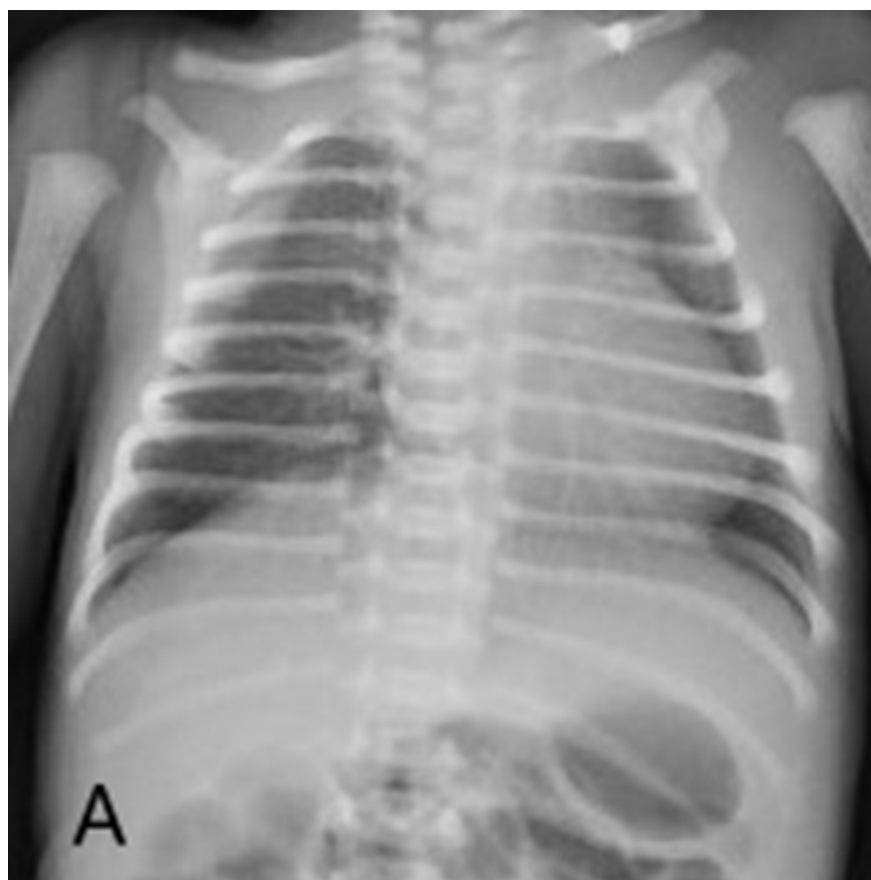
A Chest radiograph taken on birth showing reduced lung permeability and RDS (respiratory distress syndrome). B Chest radiograph taken on 24 hours after birth showed the ventilation status of the lungs was good with using a PS⁺ invasive ventilator. C Chest radiograph taken on 48 hours after birth showed no obvious abnormality. D Chest radiograph was taken on 72 hours after birth showing the infant's chest penetration is reduced, pulmonary infection, RDS secondary to an infection, and pulmonary hemorrhage are suspected.
